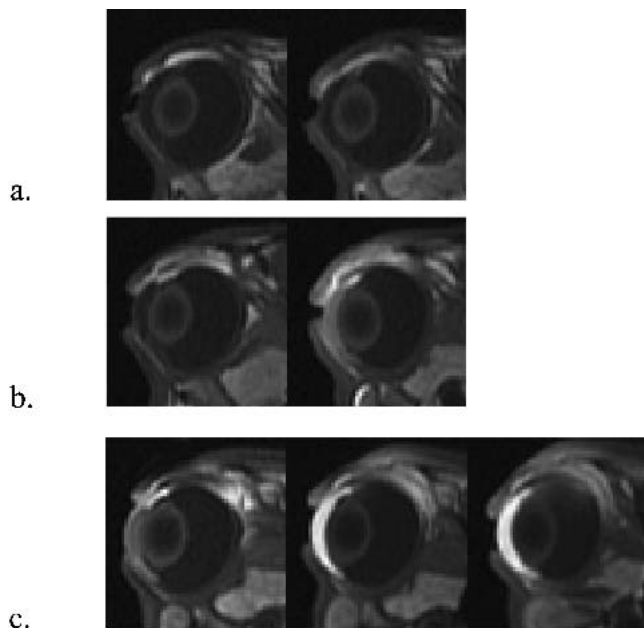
Representative MR images after subconjunctival injections of (a) 2 mM, (b) 20 mM, and (c) 0.1 M MnEDTA²⁻ solutions postmortem. From left to right: MR images obtained at (a) 30 min, 1.8 h, (b) 18 min, 1.8 h, (c) 31 min, 1.7 h, 2.6 h after injections.
